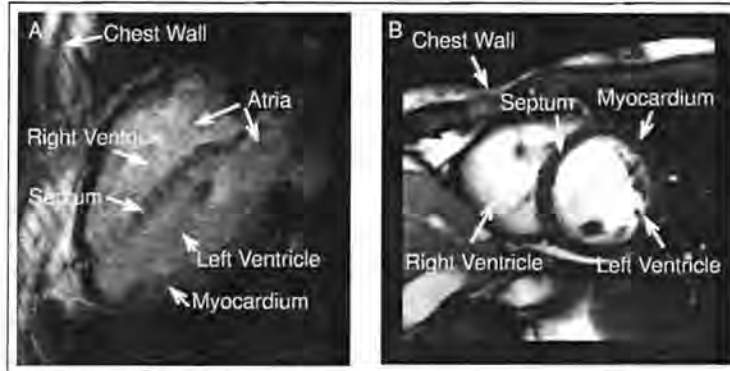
MRI images, demonstrating typical cardiac imaging views A) Long axis view of heart, B) Short axis view of the heart.
